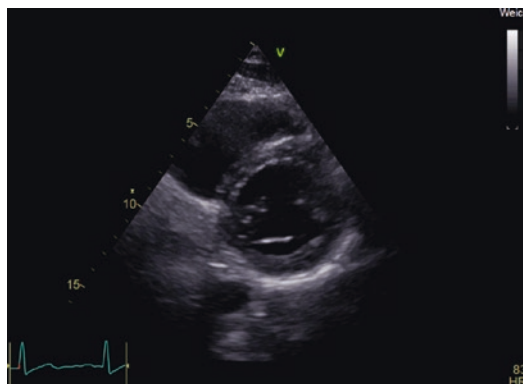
Parasternal short-axis view
